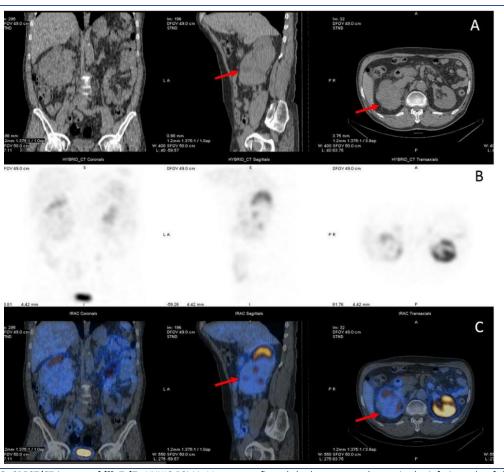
SPECT/CT images of [99mTc]Tc-HYNIC-PSMA-11 scan, confirmed the large tumoral mass in the inferior pole of the right kidney; which showed faint uptake on fused images compared to the adjacent parenchymal tissue
